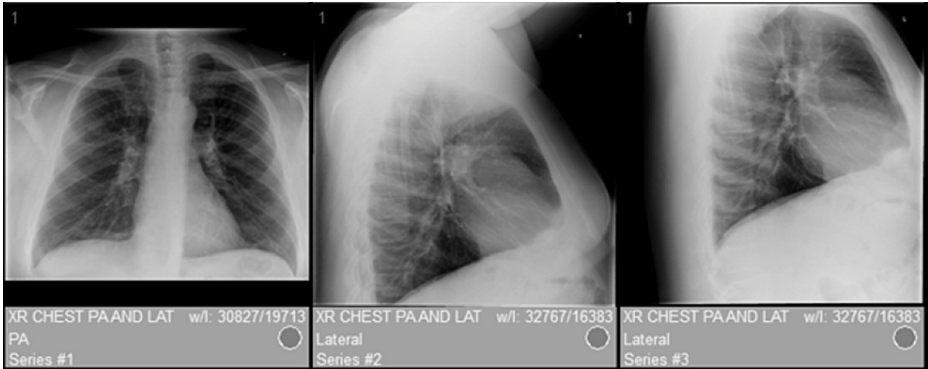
Chest X-rays showing no pathology.
